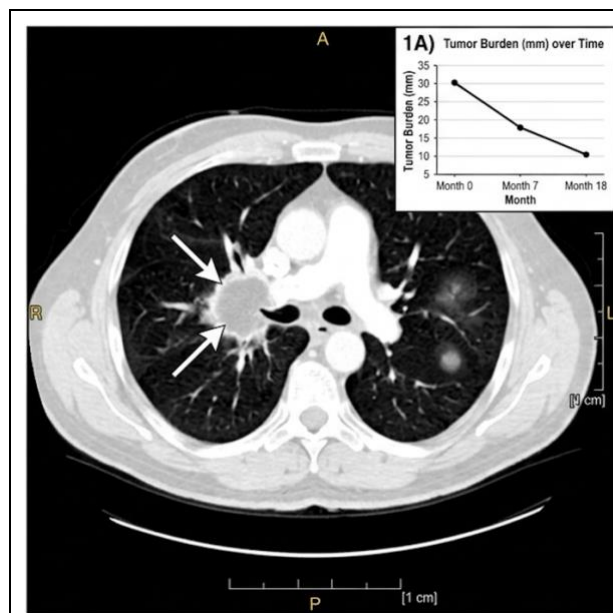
Baseline CT and Post-Treatment Response. (A) Baseline CT and Prigrt Pulmonary Thorax.
